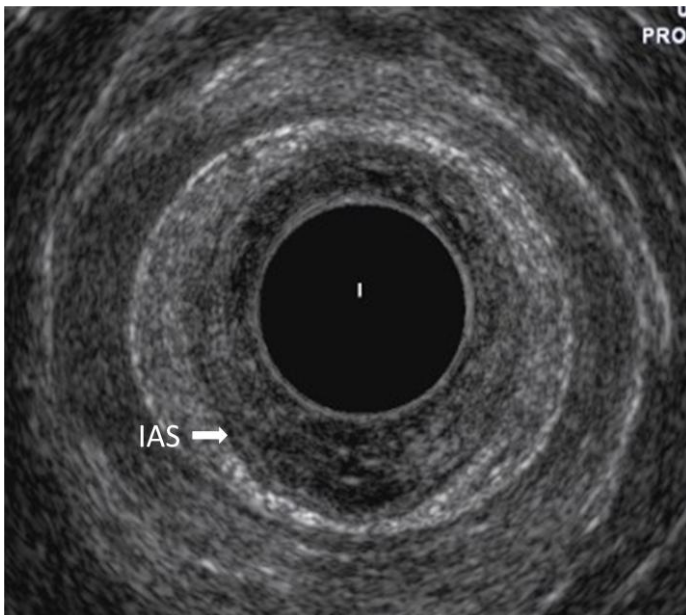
Endoanal ultrasound images showing A) EAS and IAS defect (thick arrows), IAS (black arrows), EAS (white arrows) and B) IAS atrophy (white arrow).
